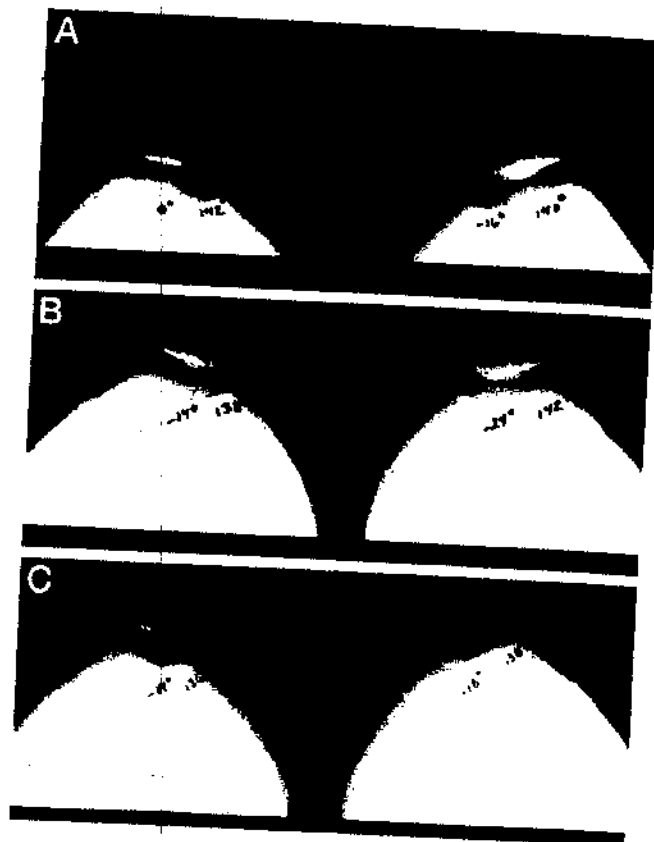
The three sequence radiographic views of a patient showing alterations in the Merchant congruence angle of the left and right knees. The left knee is the experimental knee taped with medial glide technique. A, baseline and before tape; B, after tape; C, after exercise.
